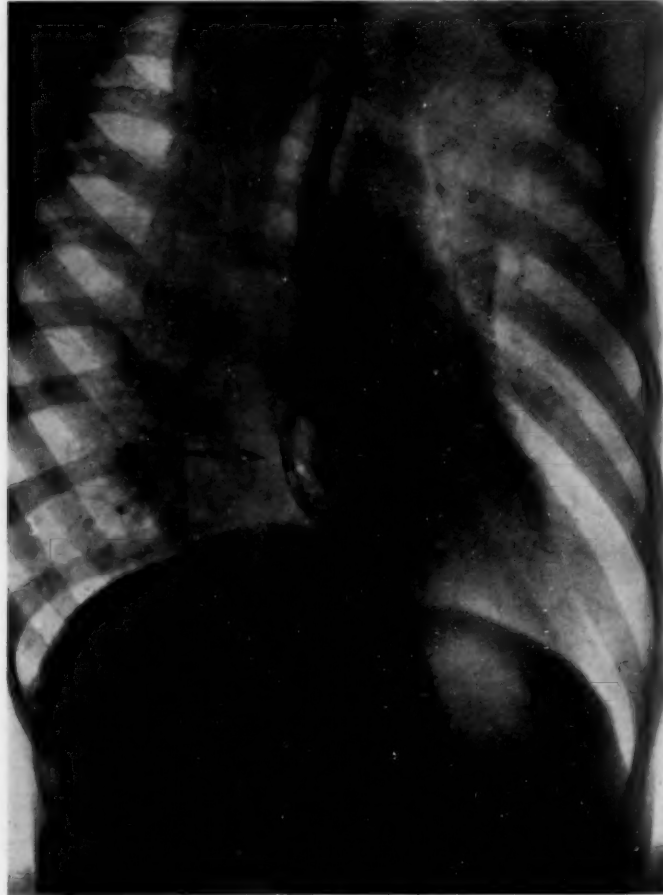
Five months after operation. The wound is healed. X-ray in oblique position, with thick barium mixture. The stricture has been dilated. The arrow points to new œsophagus.
